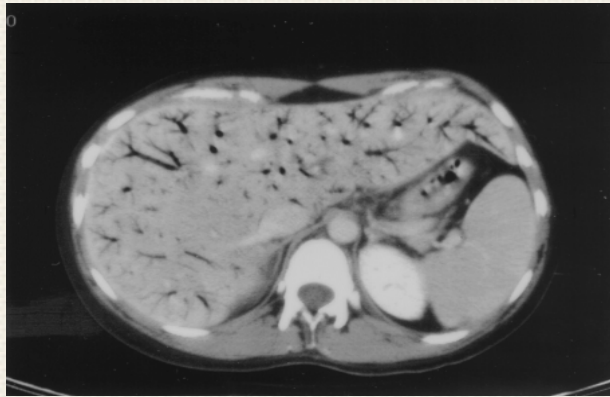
Portal venous gas on CT
